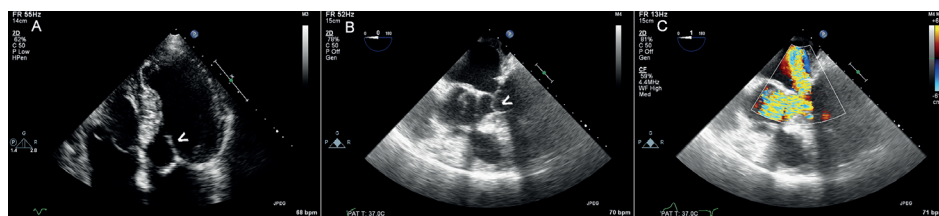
Mitral regurgitation due to systolic anterior motion (see arrowheads) in hypertrophic cardiomyopathy (A) and after mitral valve annuloplasty (B: gray-scale and C: color Doppler).
